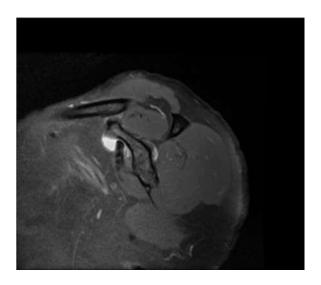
MRI image of Joint effusion
